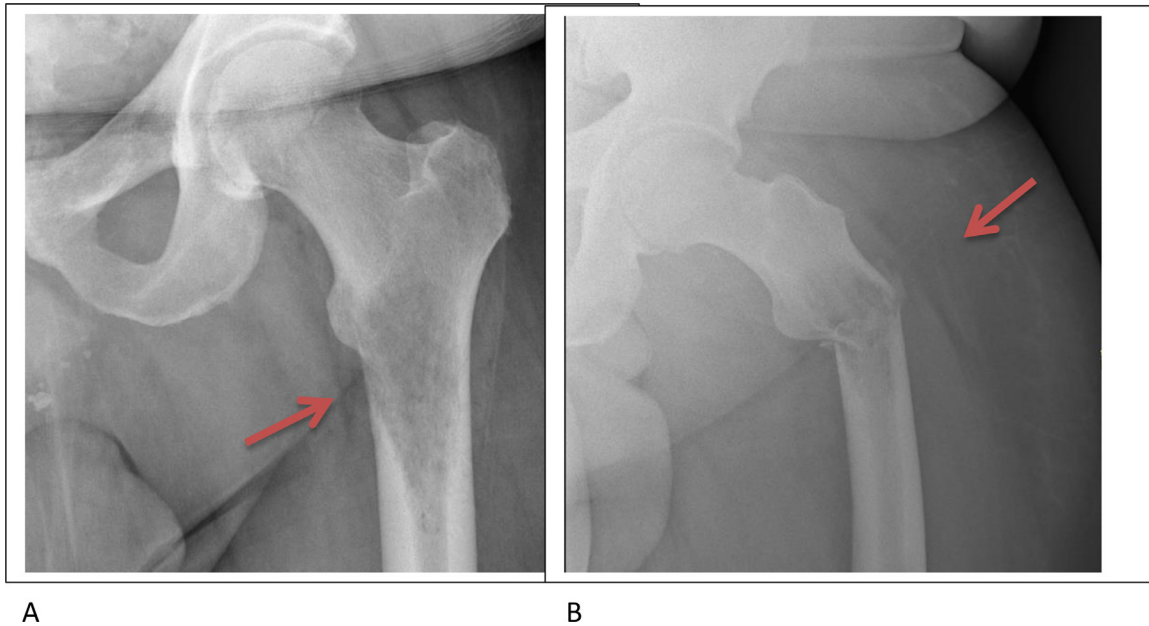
X-rays of the hip showing a lucent area around the proximal femur, with poor delineated margins, but conserved cortical bone(A) Same lesion femoral lesion few Weeks after with a pathological fracture (B).
